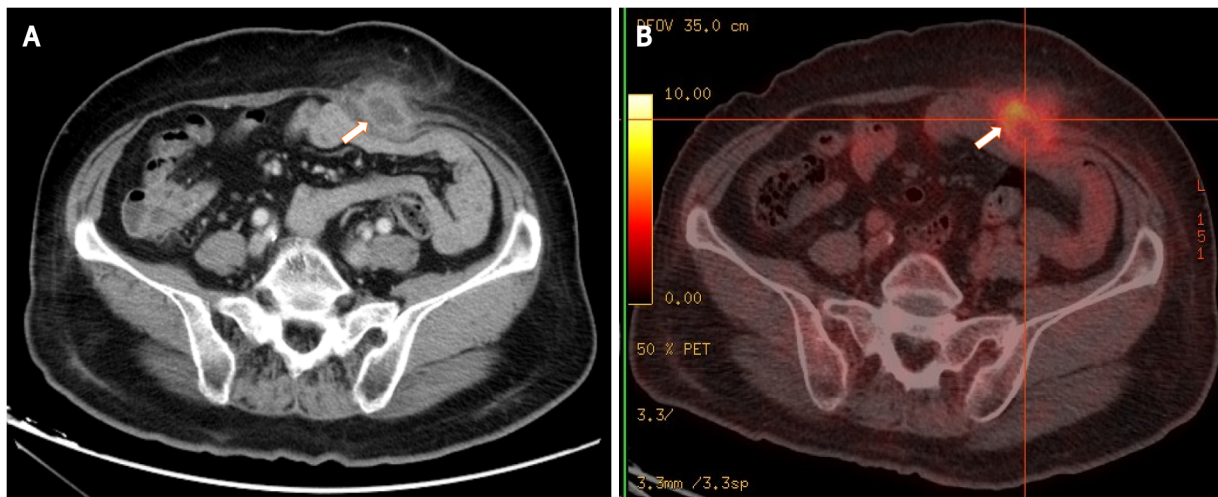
Images of the mass by contrast-enhanced abdominal computed tomography and ^{18}F -fluorodeoxyglucose-positron emission tomography. A: Computed tomography (CT) shows a low-density mass with rim enhancement adjacent to the rectus abdominis in the lower abdominal wall; B: ^{18}F -fluorodeoxyglucose-positron emission tomography/CT shows high uptake of fluorodeoxyglucose by the mass, with a maximum standardized uptake value of 6.0. The white arrows indicate the mass.
